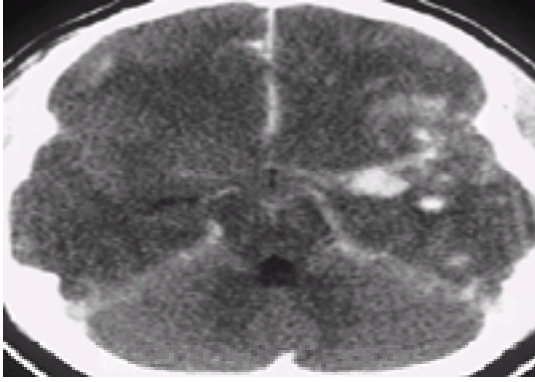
Cerebral contusion. This 16-year-old girl was comatose after being a passenger in a high-speed motor vehicle collision. A head computed tomography (CT) scan shows hemorrhagic contusion of the left temporal lobe, subdural hematoma along the tentorial margins, and effacement of the sulci throughout. The patient expired despite intensive medical management for increased intracranial pressure.
